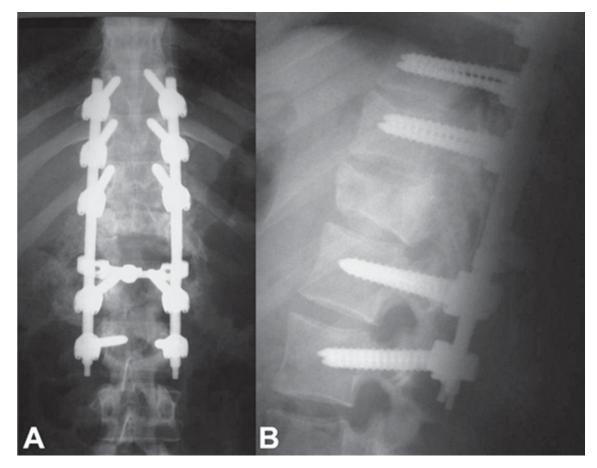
Postoperative (A) anteroposterior and (B) lateral radiographs of the thoracolumbar spine after posterior transpedicular decompression and spinal instrumentation. The patient had neurological improvement to ASIA C.
